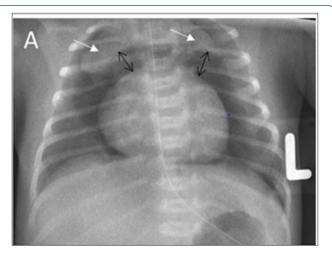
Part A-what goes up: Supine chest roentgenogram of the infant on the day of birth. Angel-wing sign (white arrows) shown as upward and lateral displacement of the thymus (black arrows).
